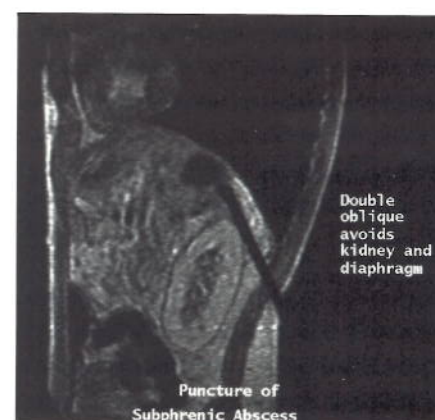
MR image of biopsy needle within pathological process.
